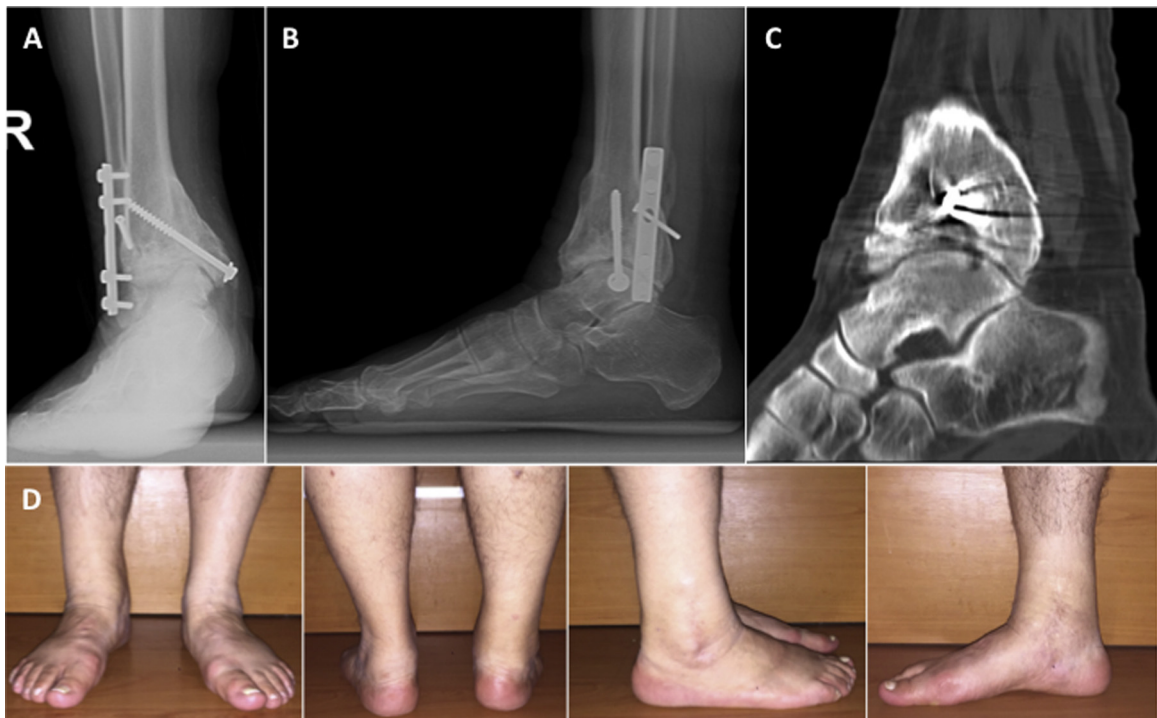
Clinical and radiological results during the final check of our patient at postoperative 14 years. Anterior–posterior and lateral radiographies of ankle (A, B), ankle's BT display (C) and ankle's clinical photographs (D).
